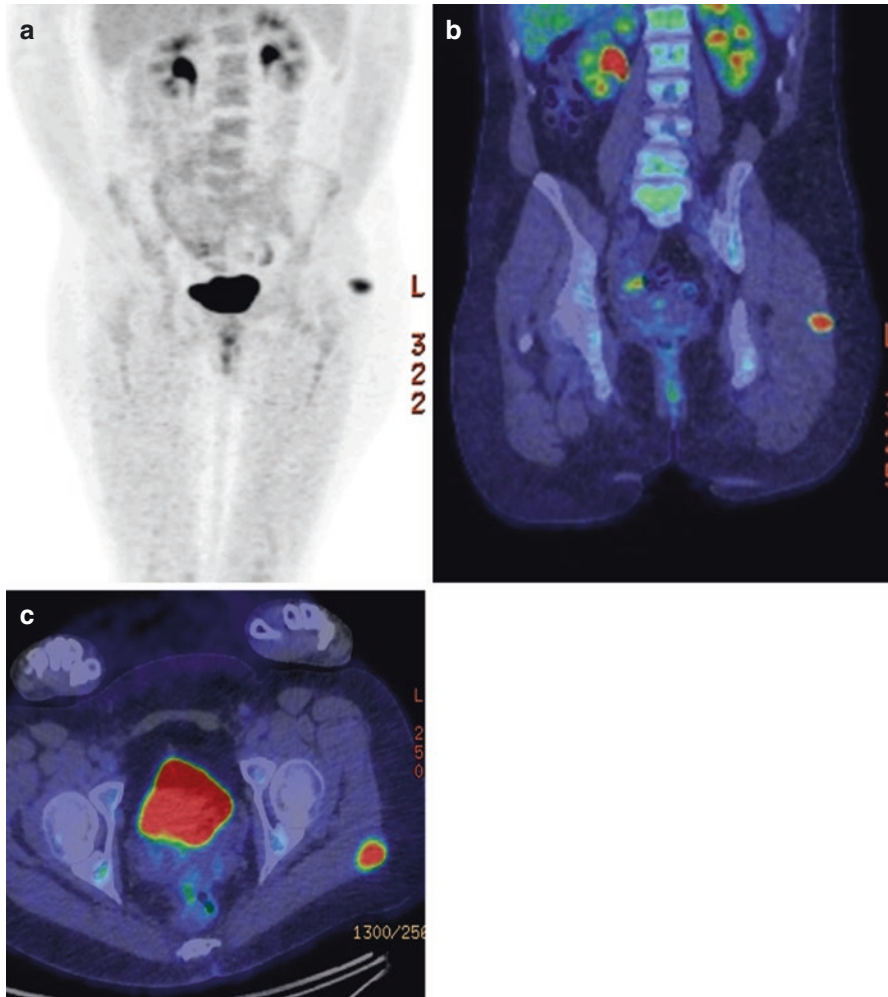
Twenty-five-year-old female with left gluteal lesion. MRI and ultrasound (not shown) demonstrated a lesion concerning for a peripheral nerve sheath tumor. Biopsy has proven malignant peripheral nerve sheath tumor (MPNST). First presentation of NF1 in this patient. (a) Attenuation-corrected PET image in coronal plane shows solitary focus of ^{18}F FDG tracer uptake in the left gluteal lesion. (b) Fused ^{18}F FDG PET/CT image in the coronal plane showing uptake in the left gluteal lesion. (c) Fused ^{18}F FDG PET/CT image in axial plane showing uptake in the left gluteal lesion
